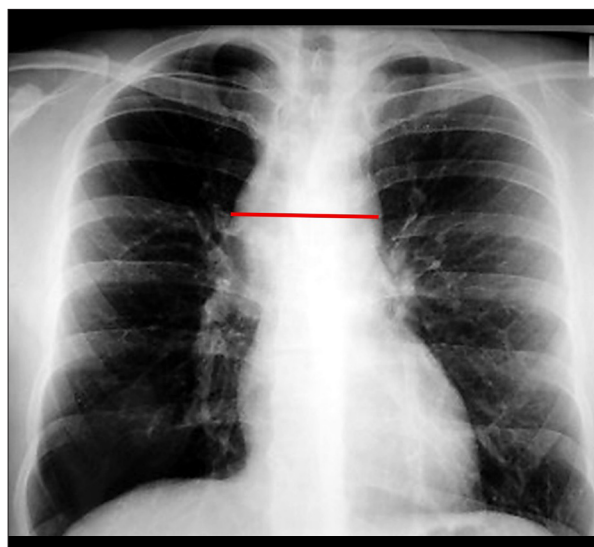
Posteroanterior chest X-ray showing widening of the mediastinum, with a shadow protruding into the right hemithorax. The line indicates the site of mediastinal widening.
